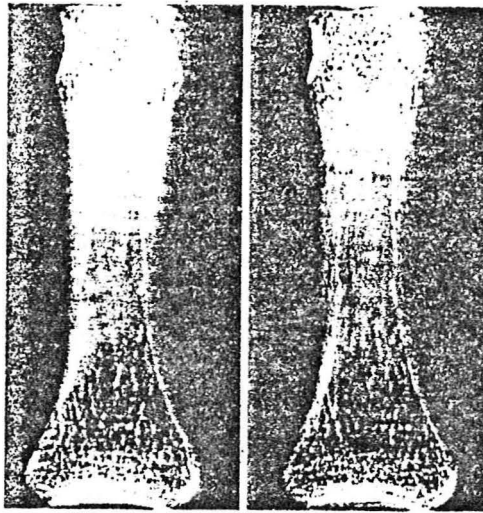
Baseline (left) and 2-year (right) magnification radiographs of the proximal phalanx of a placebo-treated woman show the development of marked intracortical resorptive tunneling or striation.
